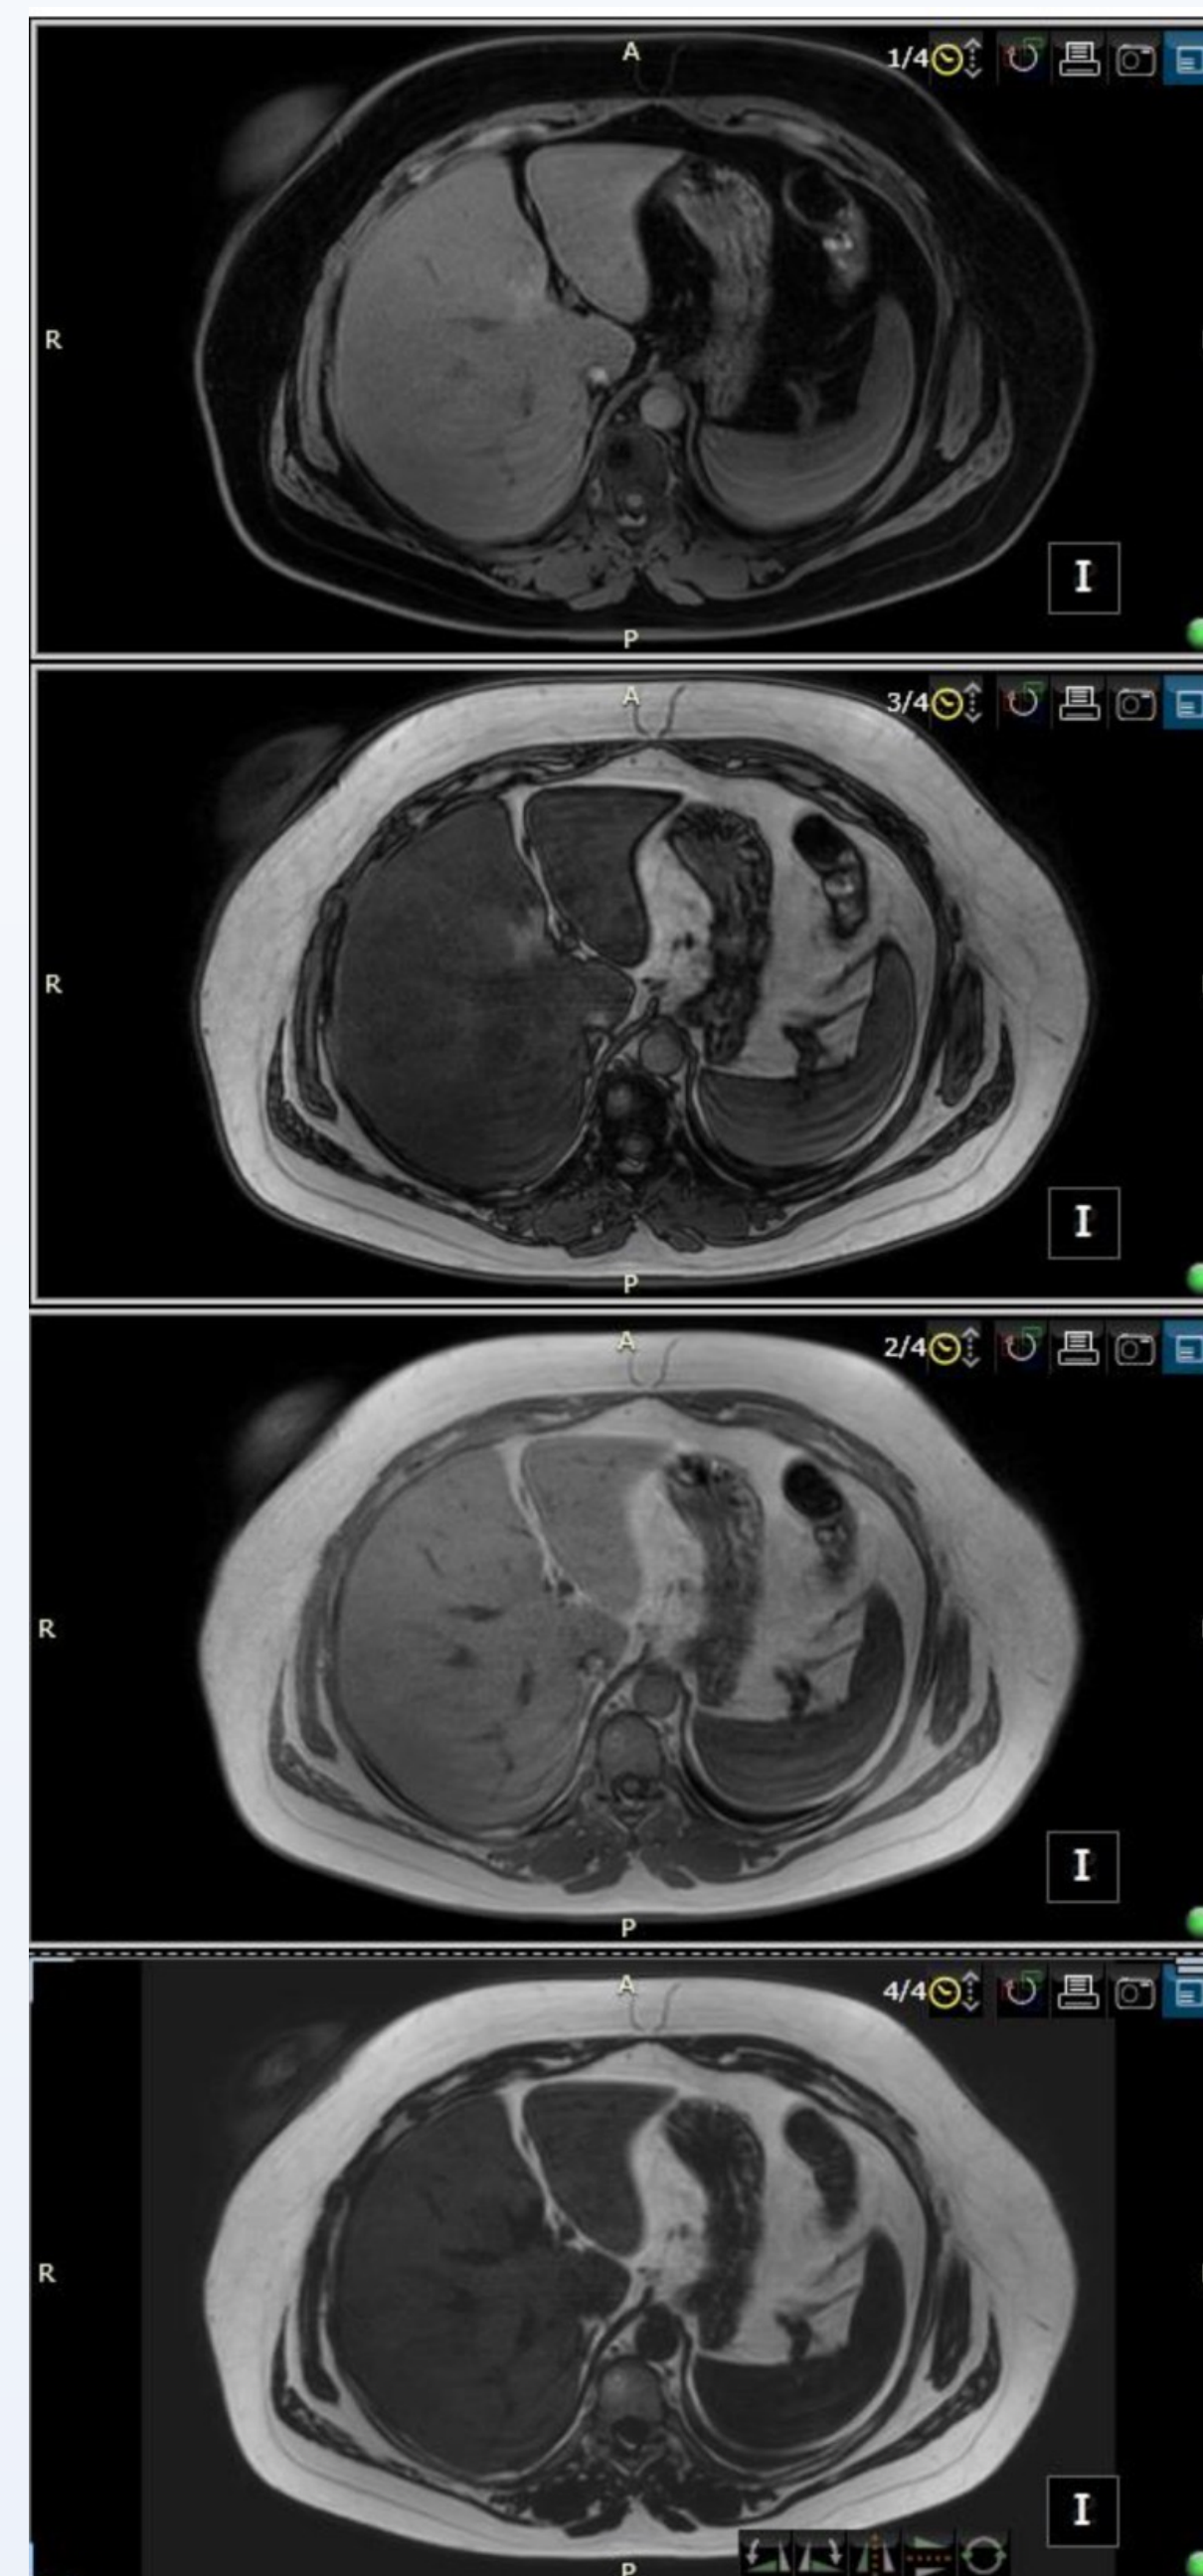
3T MRI, T1-weighted sequence qualitatively assessing liver steatosis
